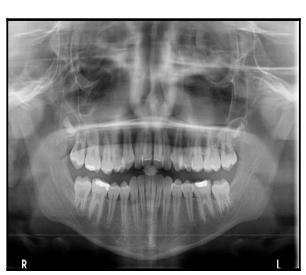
Case 1 (A) Pre-treatment OPG Radiograph.
